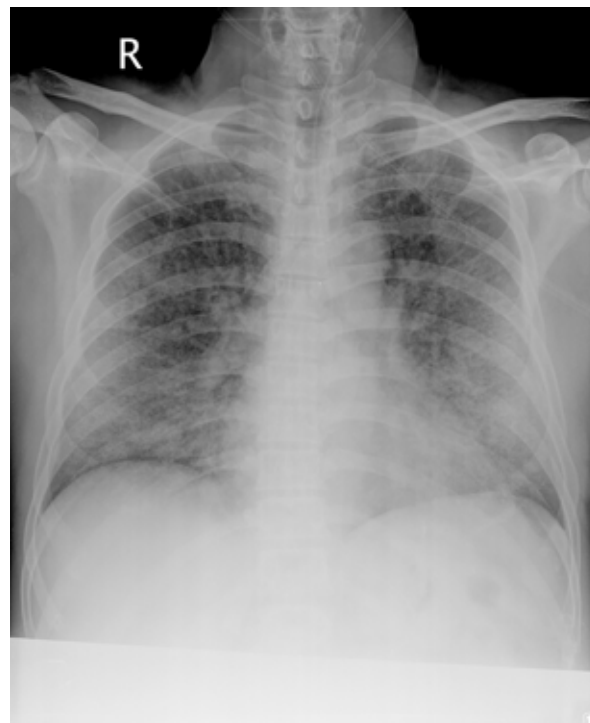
Chest radiograph showed generalized interstitial infiltrations in both lungs within the 48 hours after admission.
